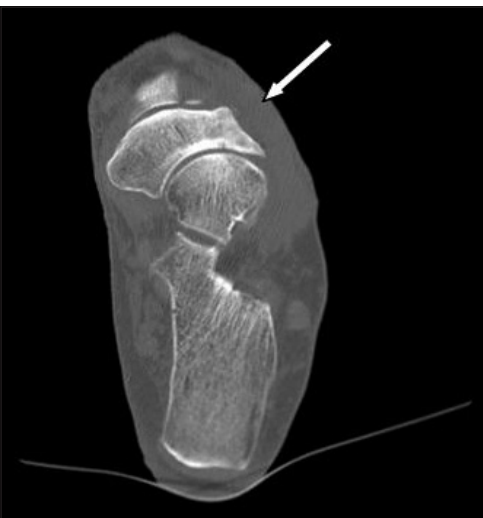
Sagittal reconstructed computed tomography (CT) image shows collapse and sclerosis of the lateral aspect of the navicular.
